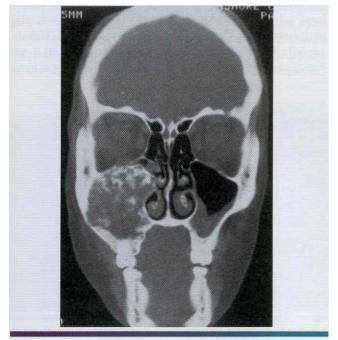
• Juvenile ossifying fibroma. Computed tomography (CT) scan showing a large tumor involving the left maxilla and maxillary sinus of a 12-year old girl. Clinically, the tumor was growing rapidly.
